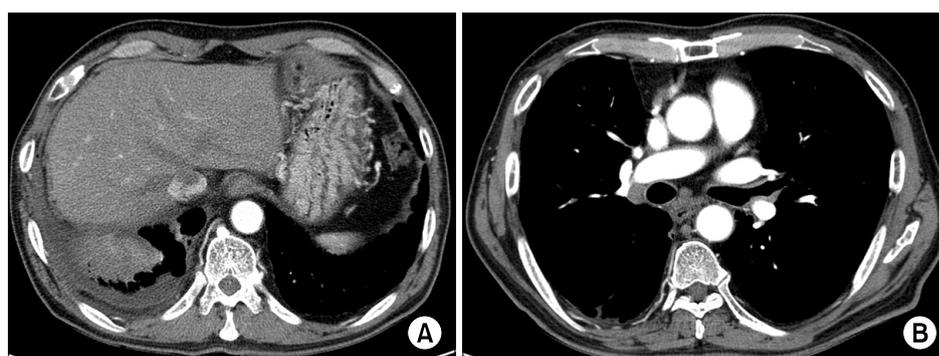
Chest computed tomography scans. Chest computed tomography scans show consolidation in right lower lobe and right pleural effusion (A) but, there is no evidence of tumor or endobronchial lesion in left bronchial tree (B).
